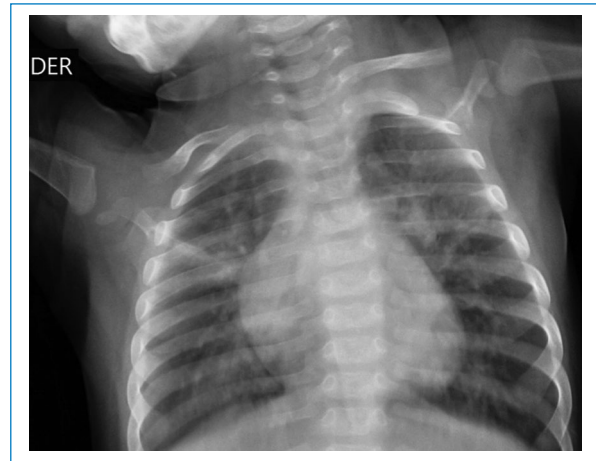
Chest X-ray in anteroposterior projection showing increased cardiac dimensions at the expense of the right chambers.
